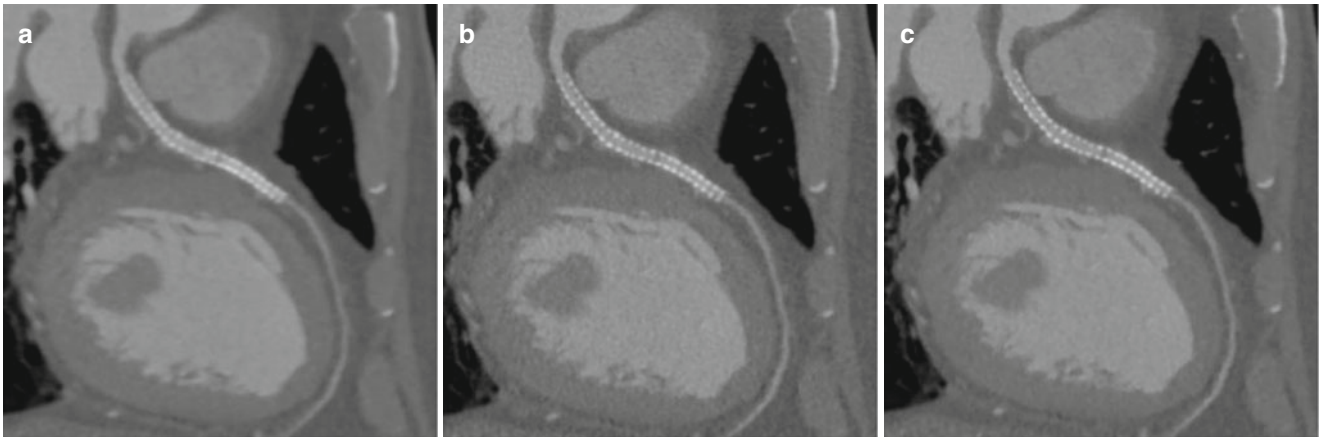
Reconstruction algorithm (Kernel). Transaxial CT images obtained with different contrast injection protocols in the same patient. (a) Curved MPR image using soft kernel (B26f) shows blooming artifacts at stent strut due to partial volume averaging effect. (b) Curved
